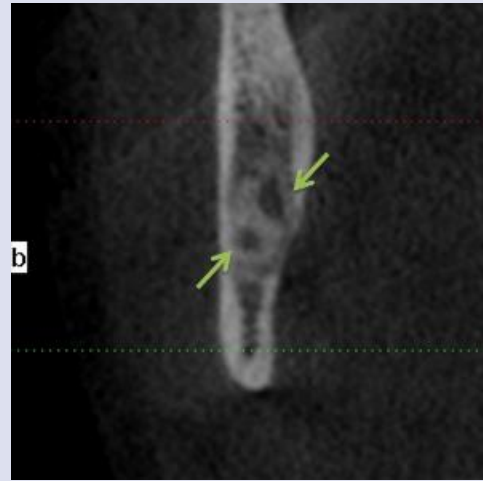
BMC on the right side of the mandible in the axial tomographic (cone-beam computerized tomography) section.
